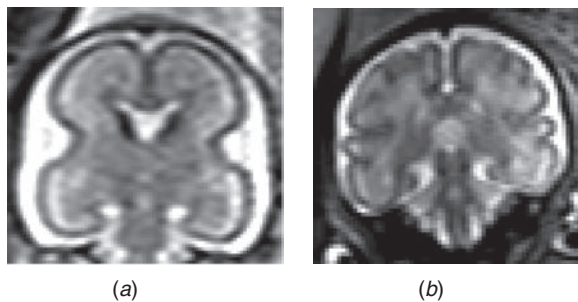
T2-weighted images in the coronal plane of the normal fetal brain at (a) 20 weeks' gestation and (b) 34 weeks' gestation showing an increase in cortical folding. The high signal intensity medial to the low signal intensity cortex represents the transient subplate. In the more mature folded cortex the subplate is only visible on the top of gyrae (b).
